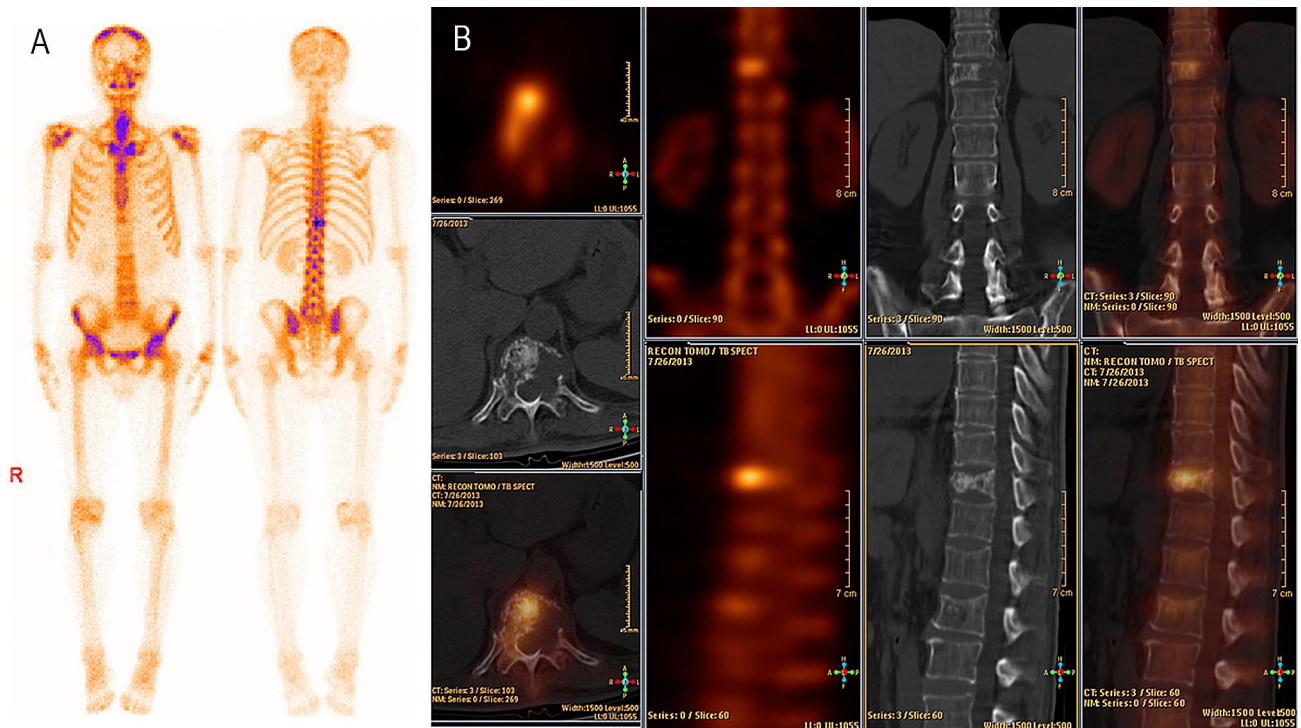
Male, 57 years old, 10 years after colon cancer surgery, low back pain without obvious cause for 2 months. Whole-body bone plane image shows 11th thoracic abnormal radioactive concentration (a). SPECT/CT image shows 11th thoracic vertebral body and left accessory osteolytic bone destruction with abnormal radioactive
